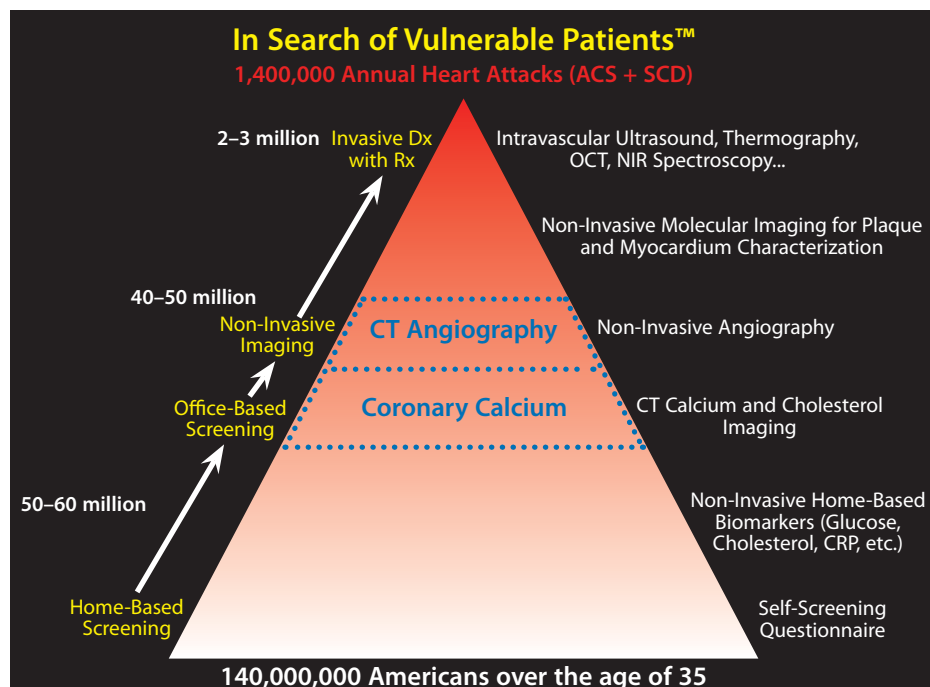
The “vulnerable patient” pyramid proposes the use of coronary calcium quantification by CT and non-invasive CT angiography for the identification of patients at intermediate risk of a heart attack, as determined by general risk scoring methods such as Framingham or PROCAM
